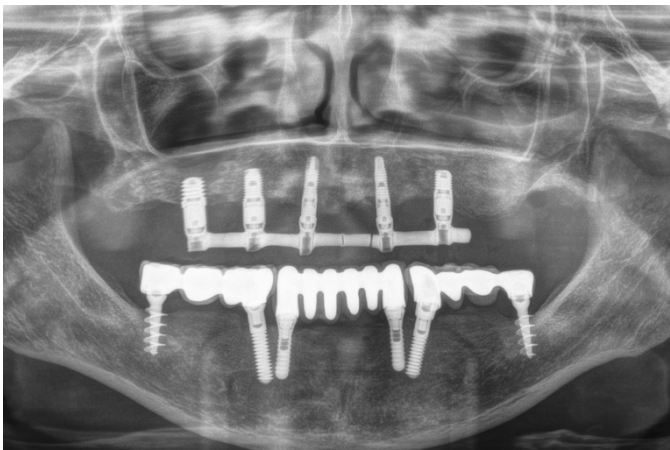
Postoperative panoramic radiograph after explantation of the upper implants and the new insertion of implants in the upper jaw and immediate load prosthesis placed 4 hours after surgery.
